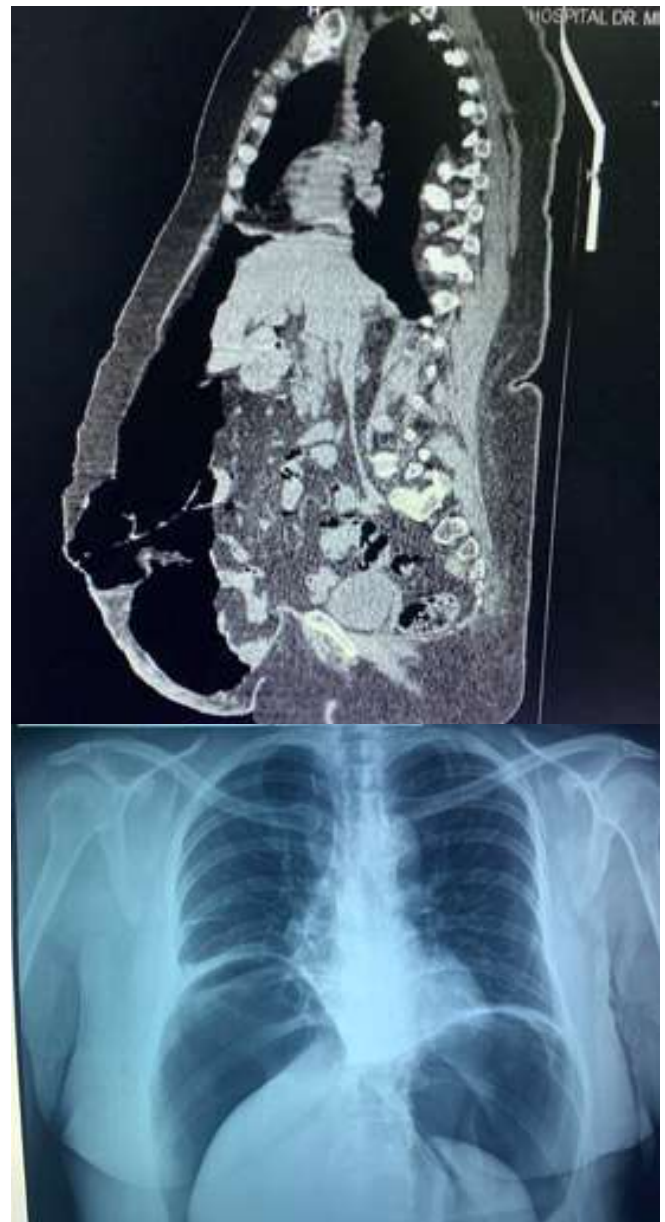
CT (upper) and X ray (lowe) after neumoperitoneum.
